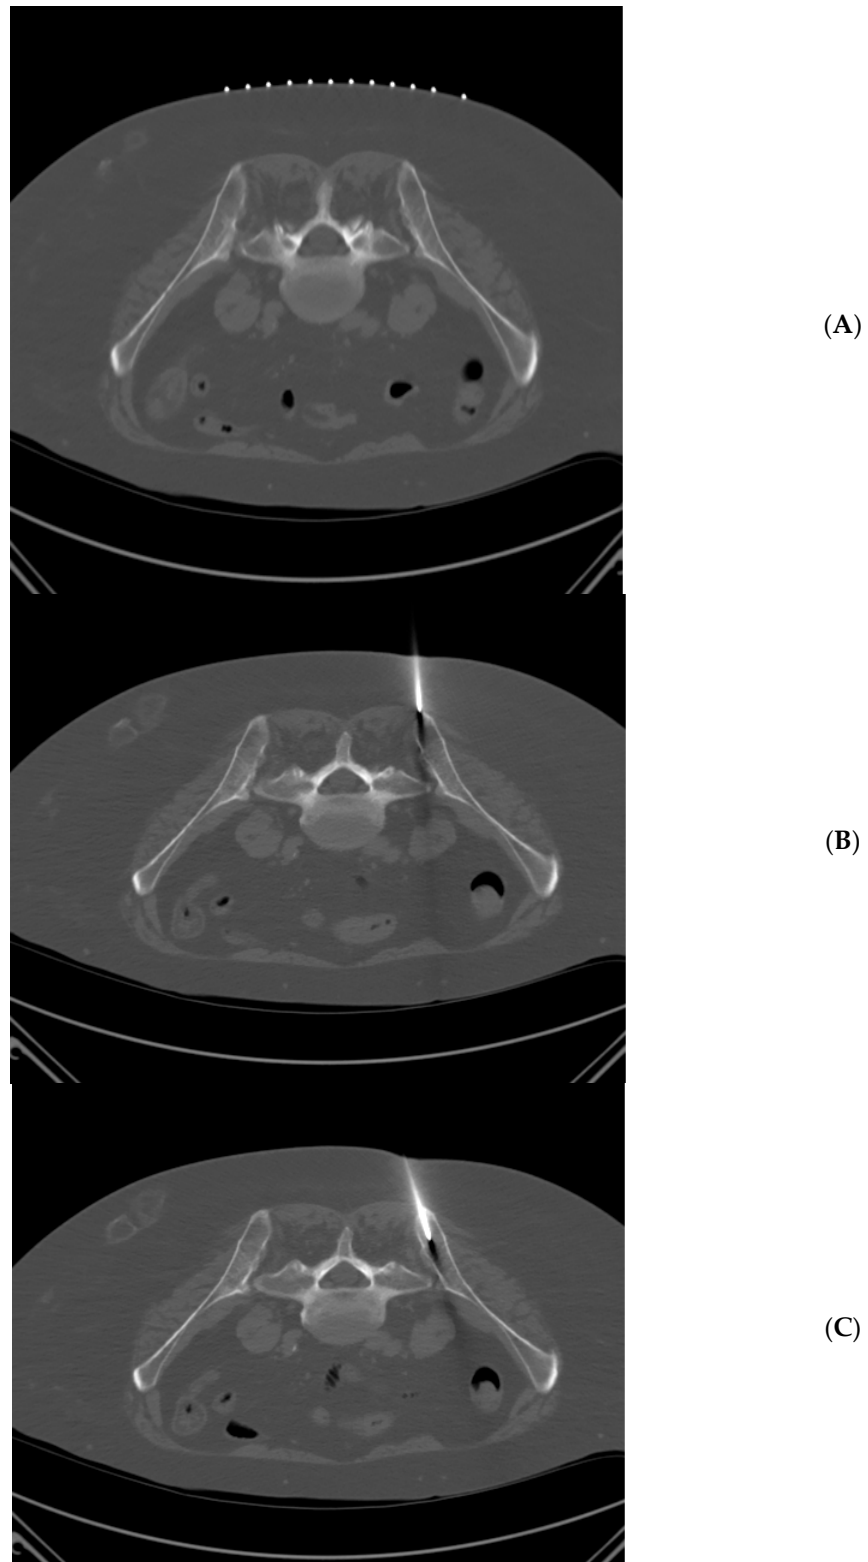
65 year-old woman with multiple myeloma. Technically successful biopsy, with adequate pathology results. (A) Prone position pre-planning CT with skin guidance markers on the left side of the patient. (B) Prone position CT with biopsy needle tip approaching left posterior iliac spine. (C) Prone position CT with biopsy needle tip within the left posterior iliac spine.
